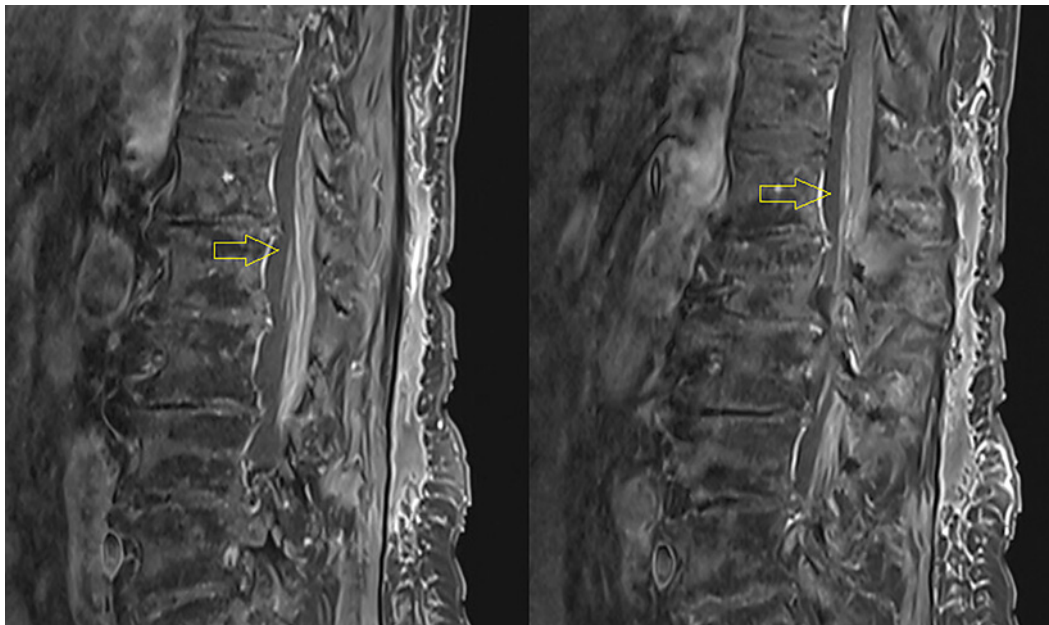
Two sagittal images from the MRI of thoracolumbar spine at time of presentation (contrast-enhanced T1-weighted sequence with fat suppression), showing contrast-enhancement of the cauda equina.
